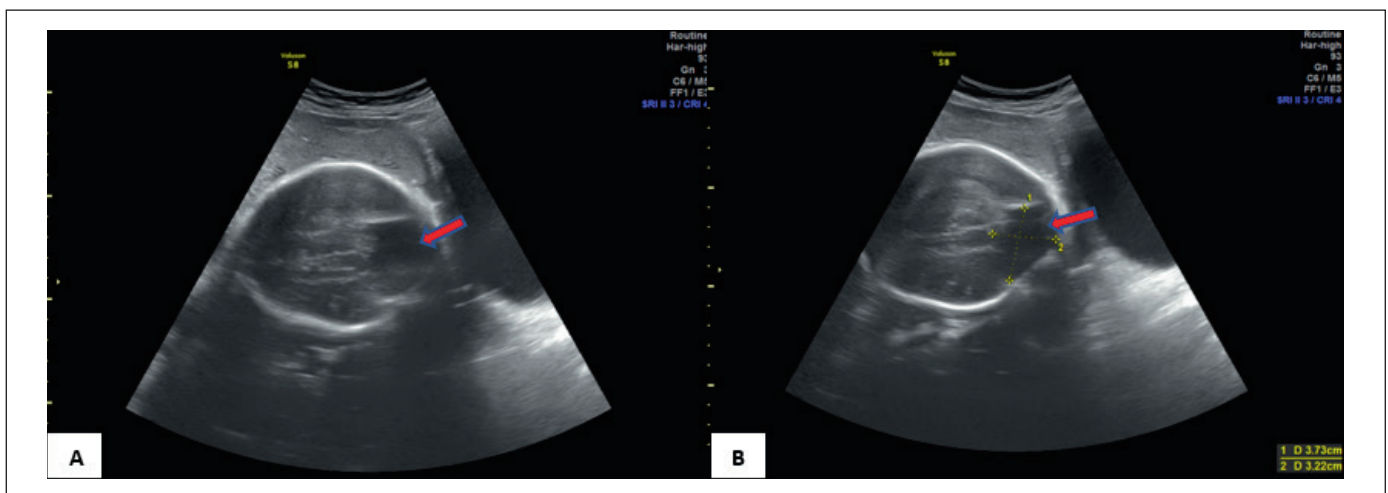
(A) Obstetric third-trimester ultrasound, and (B) presenting cystic dilatation of the fourth ventricle (pink arrows).
